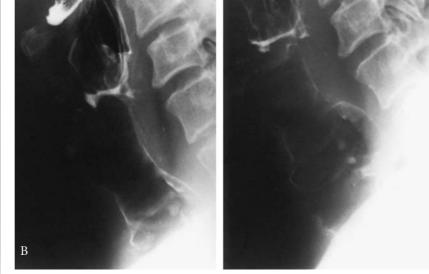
Tracheal diverticulum in a middle-aged male. The patient was asymptomatic; the finding was radiological. A, Anteroposterior roentgenogram of the larynx and upper trachea, with contrast. The diverticulum originates from the upper trachea. B, Lateral views in expiration (left) and inspiration (right).
